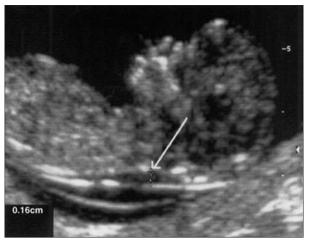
Ultrasound image showing measurement of nuchal translucency (NT) (1.6 mm) in a chromosomally normal fetus at 13 weeks. Various features of good NT ultrasound technique are evident in this image: adequate image magnification; midsagittal plane; neutral neck position; inner to inner caliper (+) placement perpendicular to the fetal body axis (*as indicated by white arrow*).
